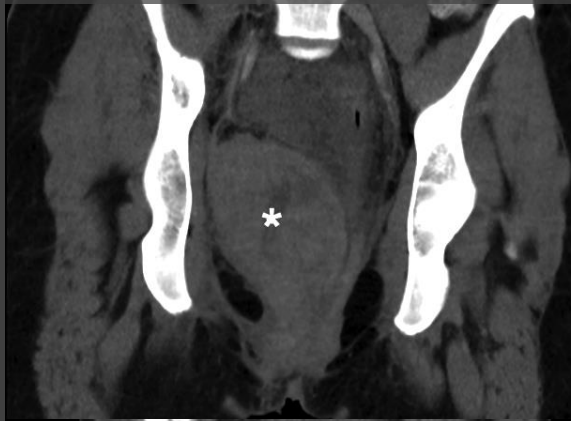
Coronal CT image of right broad ligament haematoma*, blood products in uterine cavity#, indwelling urinary catheter balloon\$
